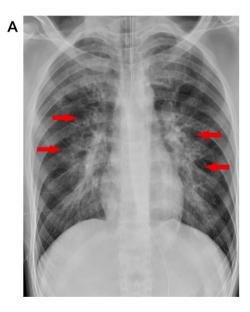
(A): Initial chest radiograph showing bilateral pulmonary edema. (arrows) (B): Chest radiologic finding at the fifth day after admission
